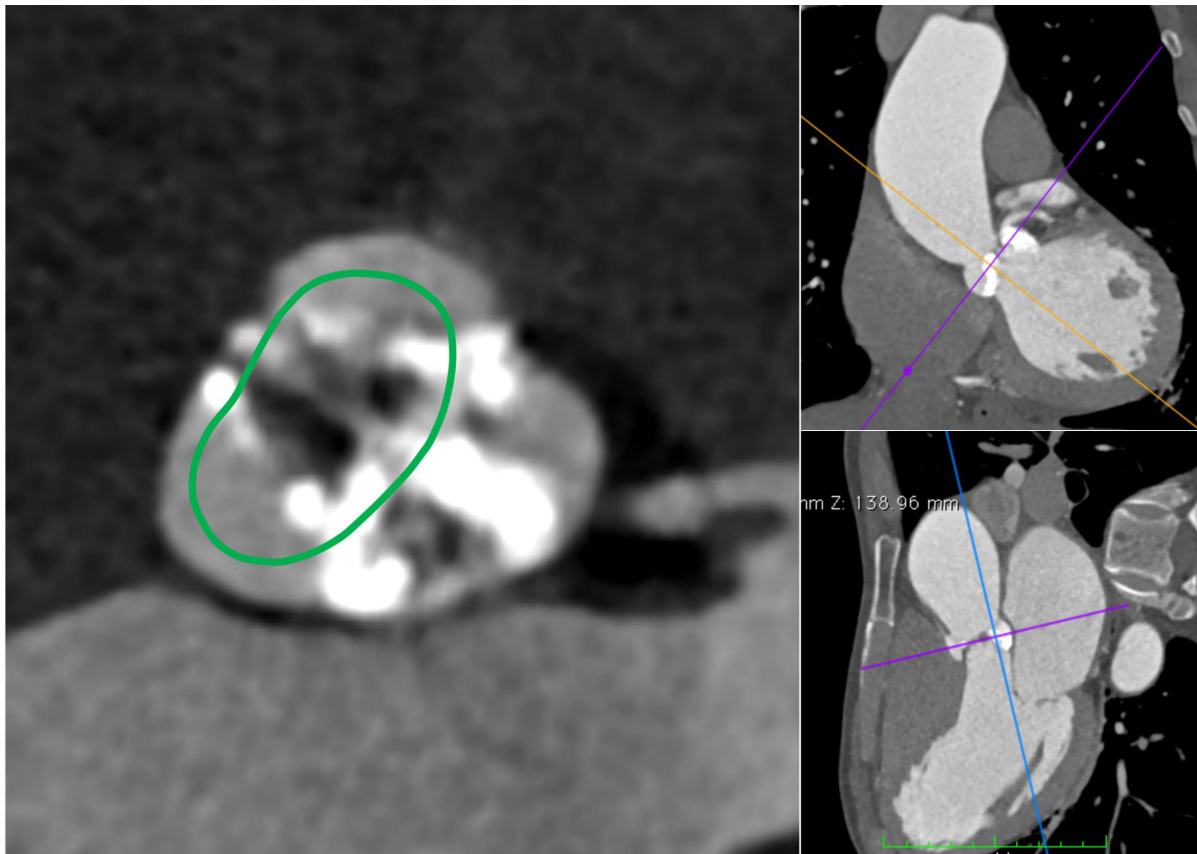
Supra-annular structure assessment based on CT measurement (note the CT images in Figs. 2,3 are from the same patient). Supra-annular area and perimeter were measured at the intercommisural distance, from which a circle is defined (green contour), and the position of supra-annular plane is shown in the CT image (purple line).
